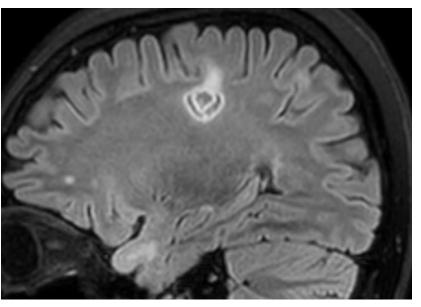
Parasagittal FLAIR image through the right centrum semiovale shows a multilayered lesion harboring concentric rings of high signal intensity interspersed with ones of lower signal intensity. There are additional and non-specific smaller high intensity lesions in the lower frontal and anterior temporal lobes.
